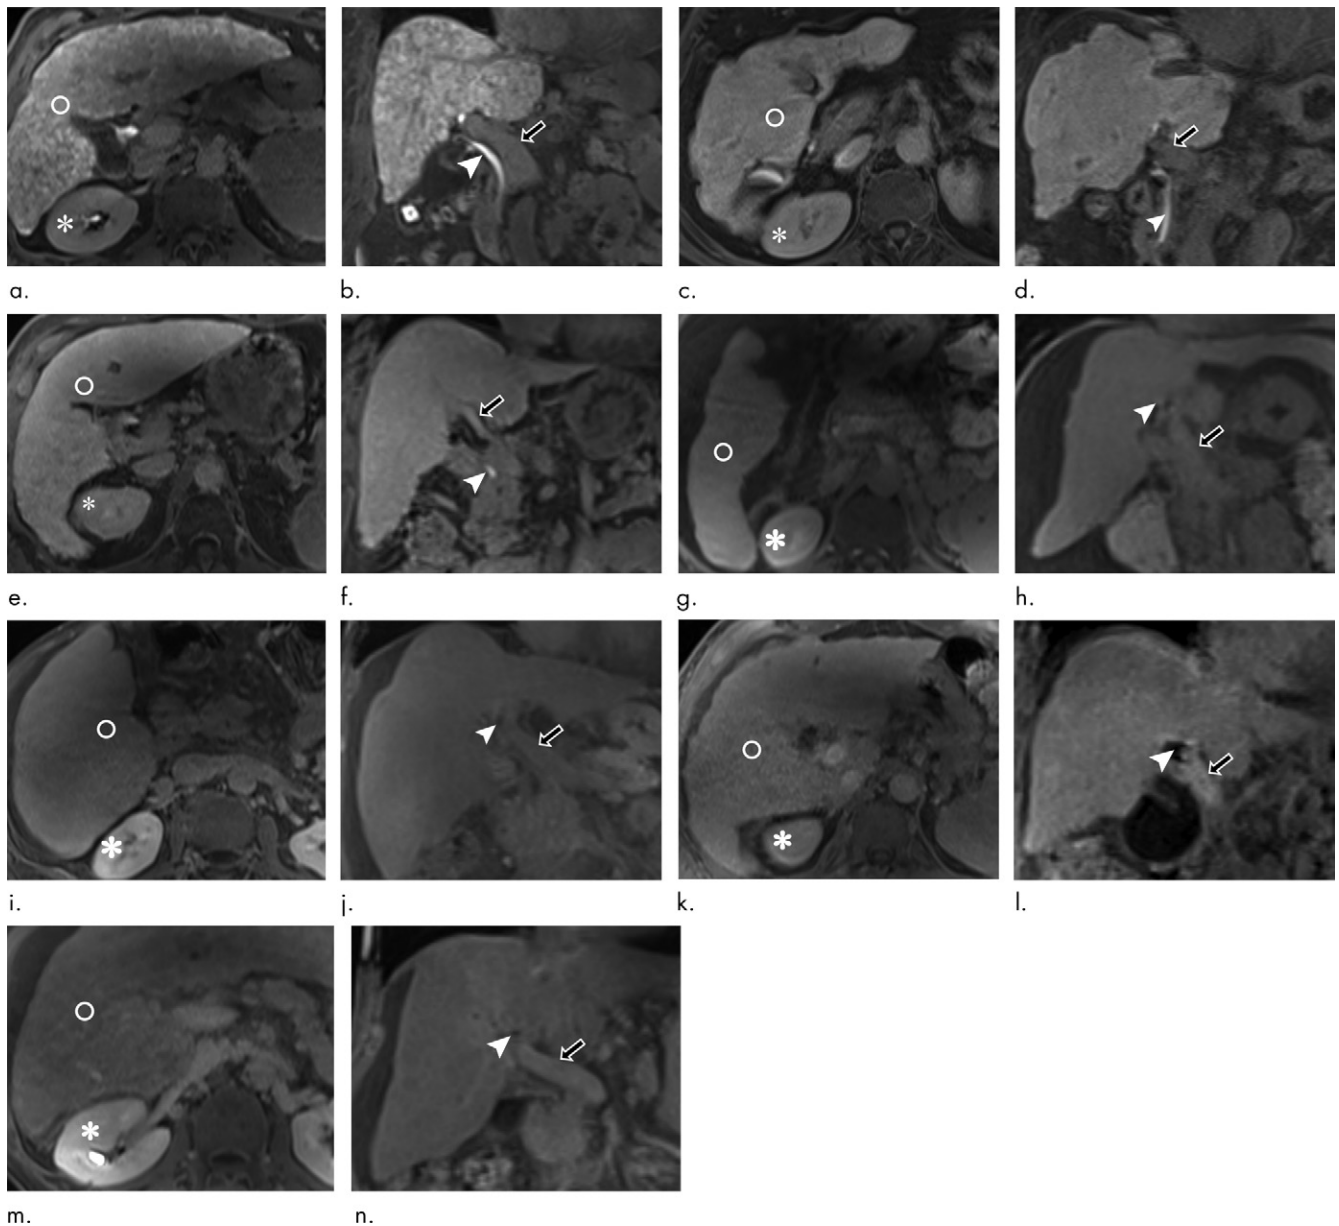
Images from 3.0-T MRI obtained 20 minutes after gadoteric acid administration in the axial and coronal planes in seven patients with advanced chronic liver disease. (a, b) A 61-year-old man with alcohol-induced cirrhosis with functional liver imaging score (FLIS) of 6; liver parenchymal enhancement quality score is 2 because the signal intensity of the liver (circle) is higher than that of the right kidney (*). Excretion quality score is 2 because contrast media is in the common bile duct (arrowhead). Portal vein sign quality score is 2 because the portal vein (arrow) is hypointense to the liver parenchyma. (c, d) Images in a 65-year-old woman with primary biliary cirrhosis. FLIS of 5. Enhancement quality score is 1 because the liver signal intensity (circle) is similar to that of the right kidney (*). The excretion quality score is 2 because contrast media is in the common bile duct (arrowhead). Portal vein sign quality score is 2 because portal vein (arrow) is hypointense to the liver parenchyma. (e, f) Images in a 52-year-old man with alcohol-induced cirrhosis. FLIS of 4. Enhancement quality score is 1 because liver signal intensity (circle) is similar to that of the right kidney (*). Excretion quality score is 2 because contrast media is in the common bile duct (arrowhead). Portal vein sign quality score is 1 because portal vein (arrow) is isointense to the liver parenchyma. (g, h) Images in a 50-year-old man with alcoholic liver disease. FLIS of 3. Enhancement quality score is 1 because the liver signal intensity (circle) is similar to that of right kidney (*). Excretion quality score is 1 because contrast media is not seen distal to intrahepatic bile ducts (arrowhead). Portal vein sign quality score is 1 because the portal vein (arrow) is isointense to liver parenchyma. (i, j) Images in a 50-year-old man with alcoholic liver disease. FLIS of 2. Enhancement quality score is 0 because the liver signal intensity (circle) is lower than that of the right kidney (*). Excretion quality score is 1 because contrast media is not seen beyond the intrahepatic bile ducts (arrowhead). Portal vein sign quality score is 1 because the portal vein (arrow) is isointense to liver parenchyma. (k, l) Images in a 50-year-old man with cirrhosis from nonalcoholic steatohepatitis. FLIS of 1. Enhancement quality score is 1 because liver signal intensity (circle) is equal to that of the right kidney (*). Excretion quality score is 0 because no contrast media is seen in the biliary tree (arrowhead). Portal vein sign quality score is 0 because the portal vein (arrow) is hyperintense to the liver parenchyma. (m, n) Images in a 69-year-old man with hepatitis C virus cirrhosis. FLIS of 0. Enhancement quality score is 0 because the liver signal intensity (circle) is less than that of the right kidney (*). Excretion quality score is 0 because no contrast media is in the biliary tree (arrowhead). The portal vein sign quality score is 0 because portal vein signal intensity (arrow) is greater than that of the liver parenchyma.
